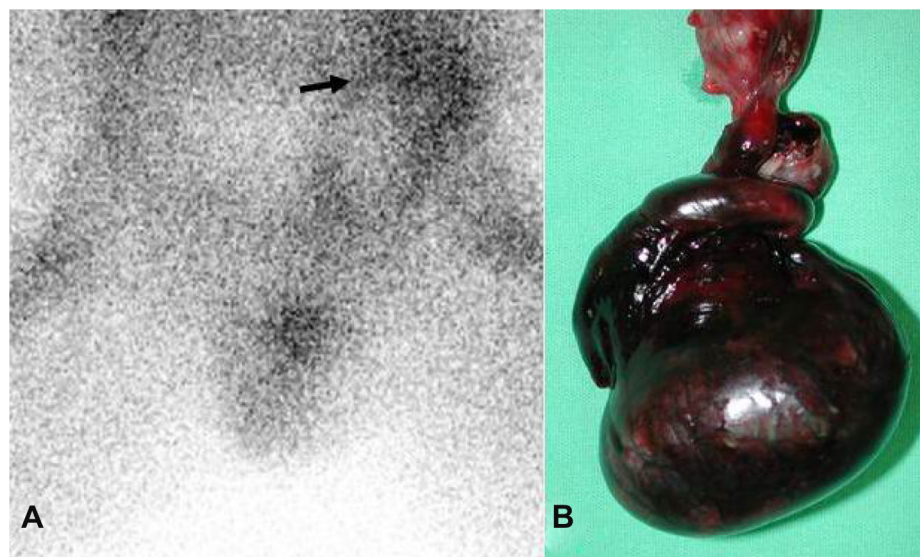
(A) Technetium Tc-99m scrotal scintigraphy shows asymmetric mildly increased vascularity in the left inguinal portion, with no evidence of torsion. It was not compatible with our clinical judgment. (B) Surgical exploration was performed and perioperative findings revealed a gangrenous, torsional left testicle within the inguinal canal.
